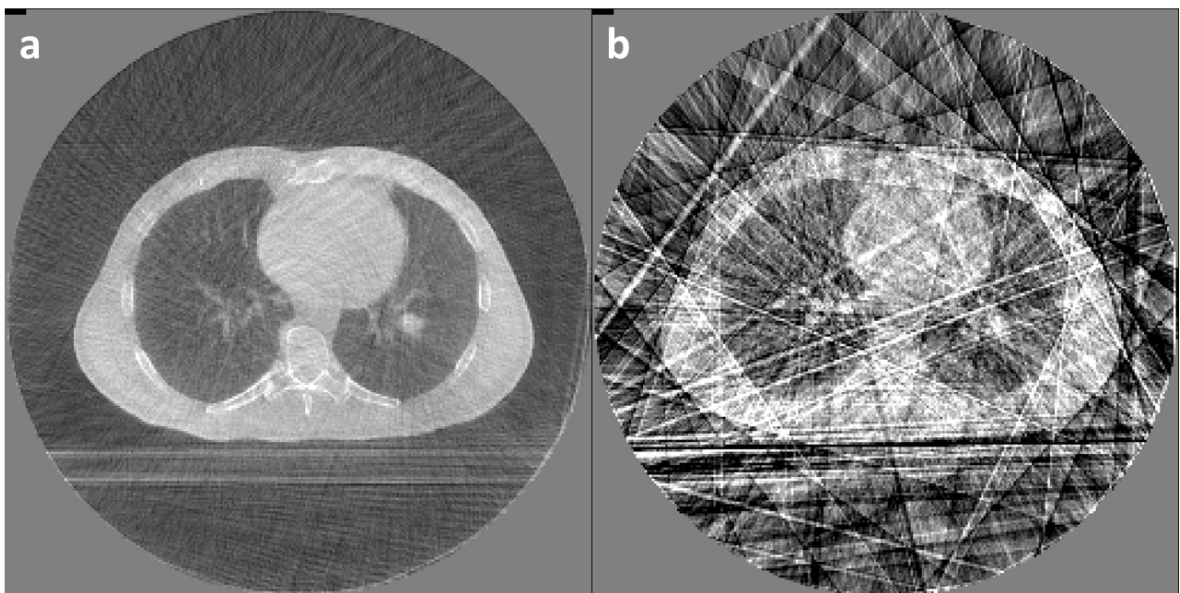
Comparison of 3D (a) and 4D phase (b) CBCT axial image. Prominent streak artifacts are present in the phase image due to under-sampling and uneven projection spacing.
